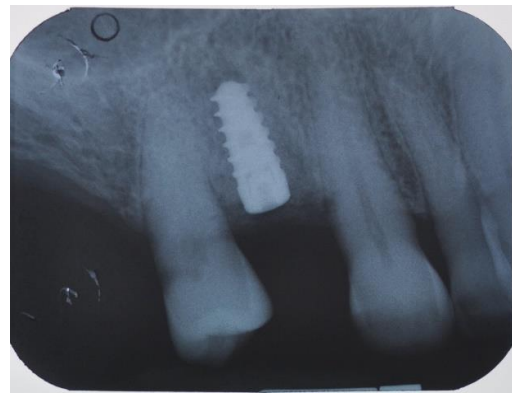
Case 1. Radiographic control of regeneration.
